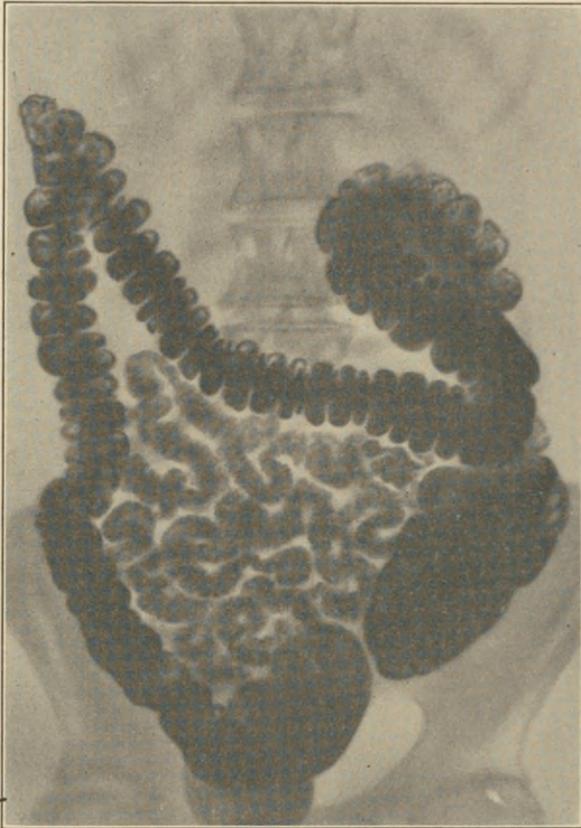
ROENTGENOGRAM SHOWING CASE OF COMPLETELY INCOMPETENT ILEOCECAL VALVE. This shows filling of entire small intestine with barium enema; clinical symptoms very marked.
